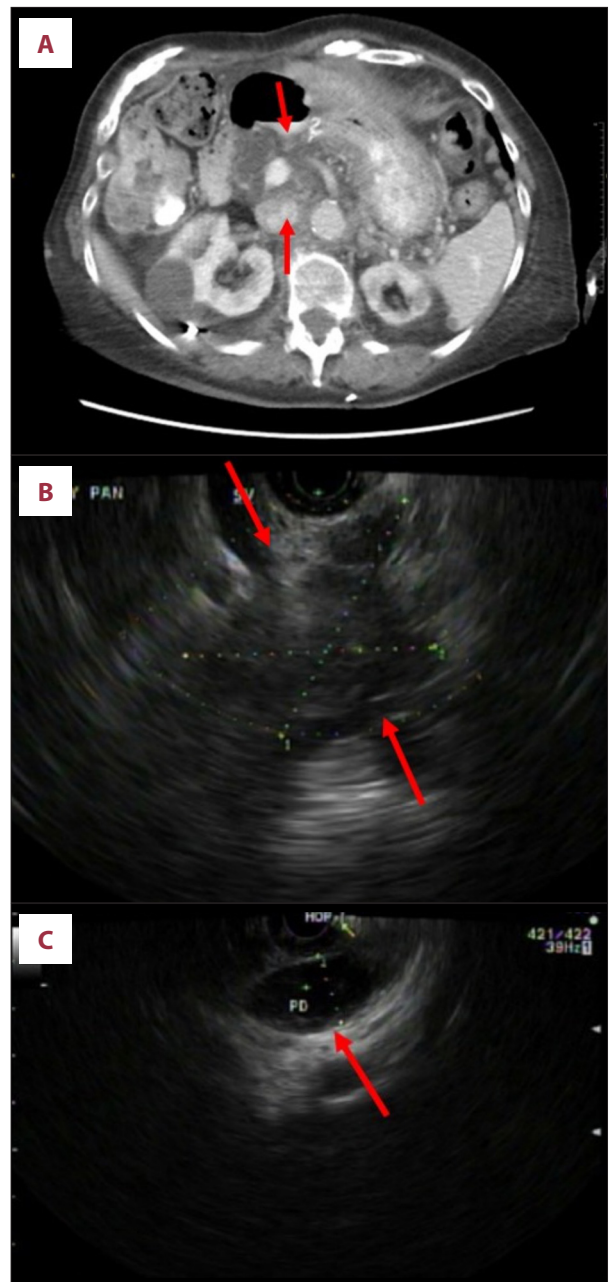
(A) Abdominal CT showed 4.7-cm multiloculated cystic lesions in the pancreas head/body (arrow). (B) Endoscopic ultrasound showed a heterogeneous solid and cystic mass, similar in size to that visualized by the CT scan, in the pancreatic body (arrows). (C) The pancreatic duct was dilated to 15 mm (arrow).
